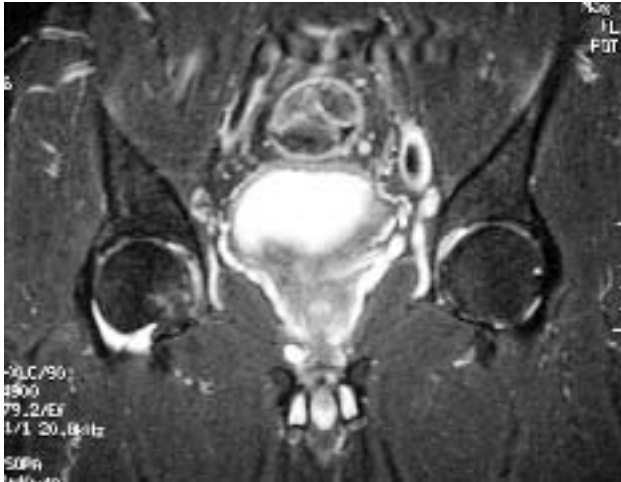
Bone marrow edema limited to the femoral head is observed in this fat-suppression coronal T₂-weighted MRI obtained from a 49-year old male patient complaining of hip pain for 5 months. The subchondral area is noticed to be spared by the femoral head bone marrow edema.
